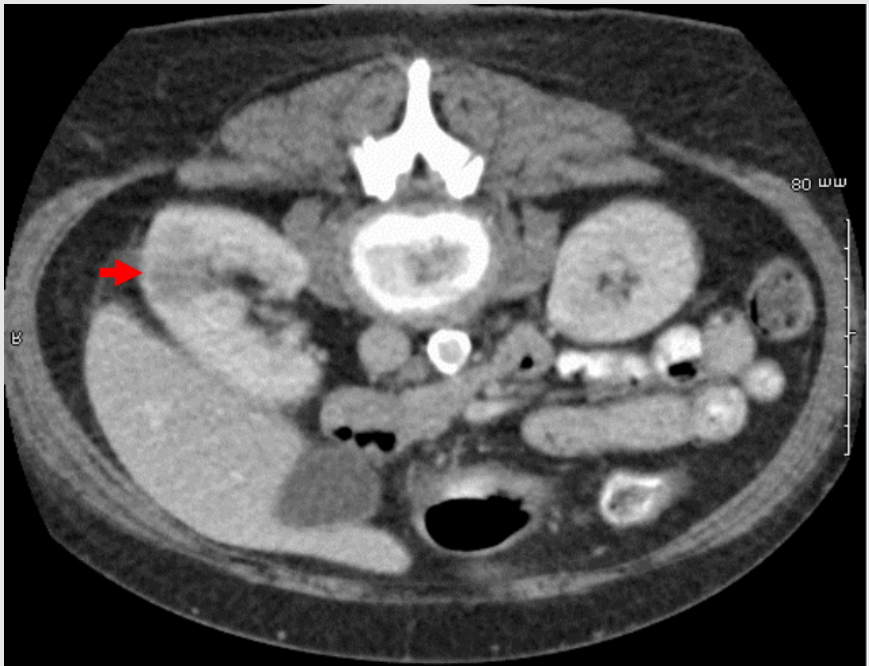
CT visualization of a 1.8 cm right renal mass (red arrow) in a newly diagnosed lung cancer patient.
